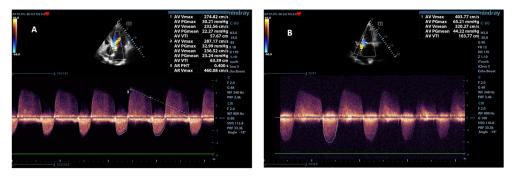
b.5. Transvalvular aortic velocity and mean pressure gradient in two cases: mild aortic stenosis [ $V_{mx}$ =2.7 m/s, MPG=22.27 mmHg (A)] and severe aortic stenosis [ $V_{mx}$ =4.01 m/s, MPG=44.22 mmHg (B)] (5-chambers view, continuous Doppler in patients with concomitant aortic regurgitation)
